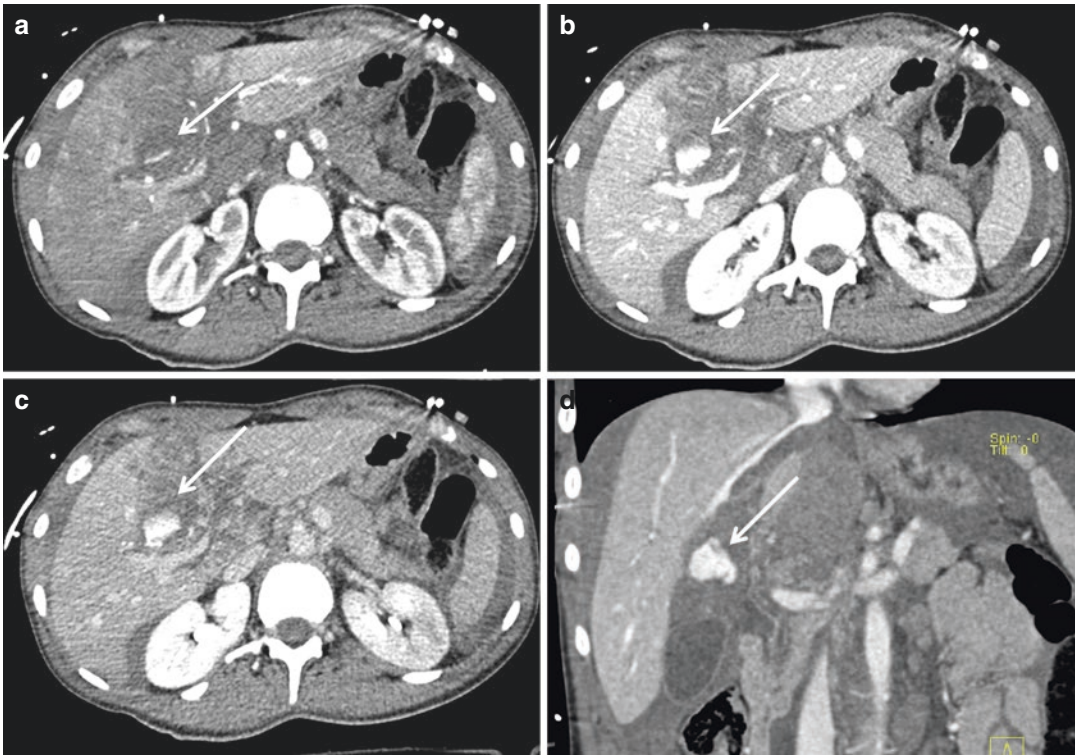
Active bleeding: the extravasation of contrast in the arterial phase (a) becomes stronger in the venous (b), and the equilibrium (c), phases. (d) Coronal CT reconstruction confirms the active bleeding (arrow)
